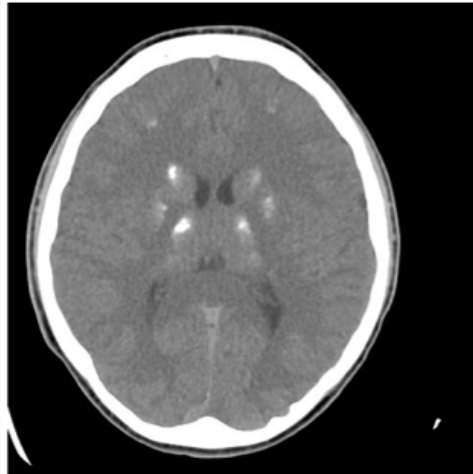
CT brain axial view.
